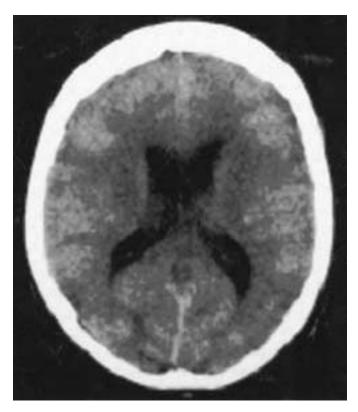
Computed tomography scan of primary diffuse leptomeningeal gliomatosis. The image exhibits slight ventricular dilatation but no other abnormalities are present.
